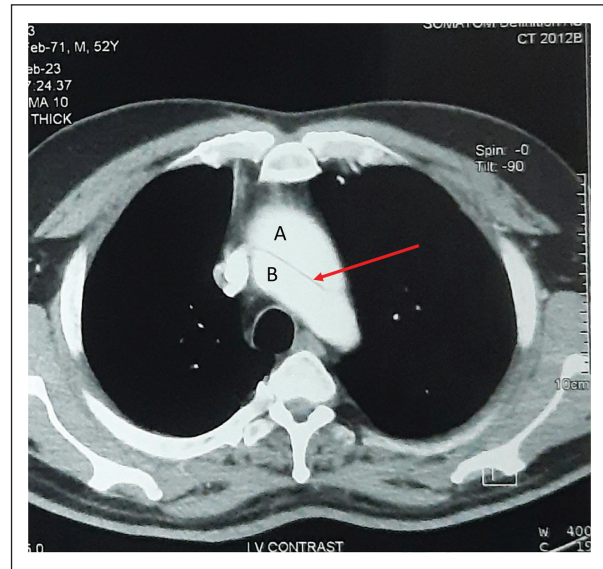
Contrast-enhanced CT showing aortic dissection. A: false lumen; B: true lumen; red arrow: the intimal flap; CT: computed tomography.
